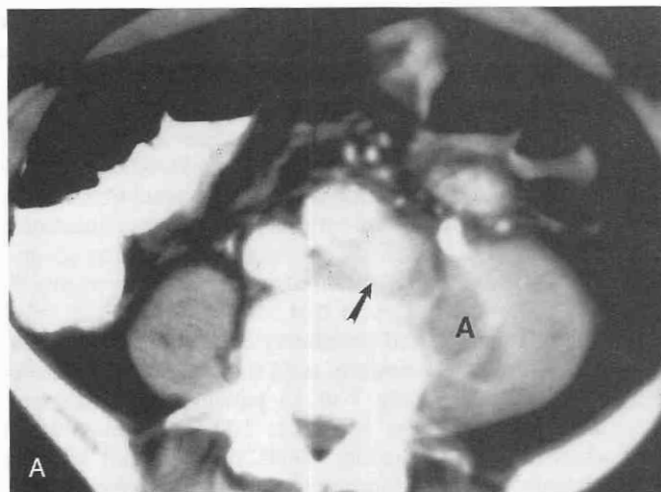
Mycotic abdominal aortic aneurysm. A, CT scan of a left psoas abscess (A) in a 66-year-old man also demonstrates a mycotic aneurysm as a focal outpouching of contrast-enhanced blood from the left posterolateral aspect of the aorta (arrow). B, A digital subtraction image from an aortogram better demonstrates the irregular shape of this mycotic aneurysm (arrow).
